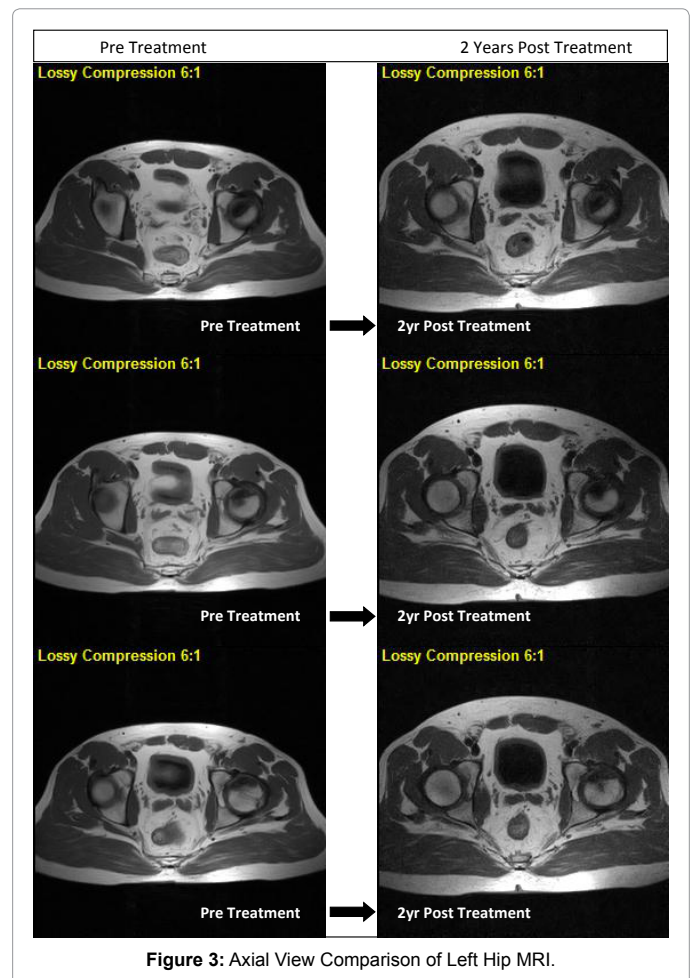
Axial View Comparison of Left Hip MRI.
